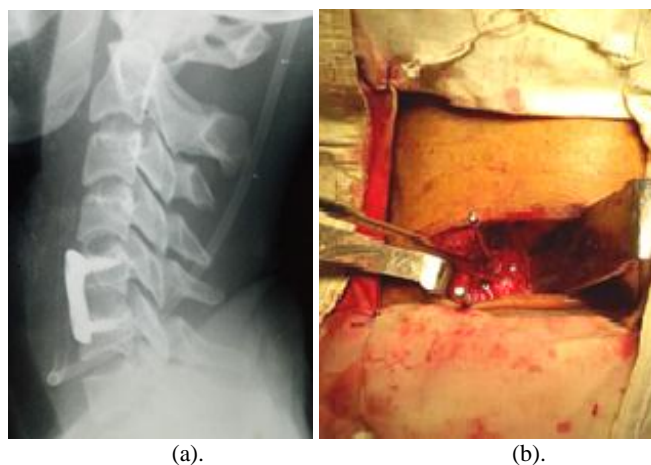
Postoperative X-ray with plate & screw (a) and per-operative picture.
